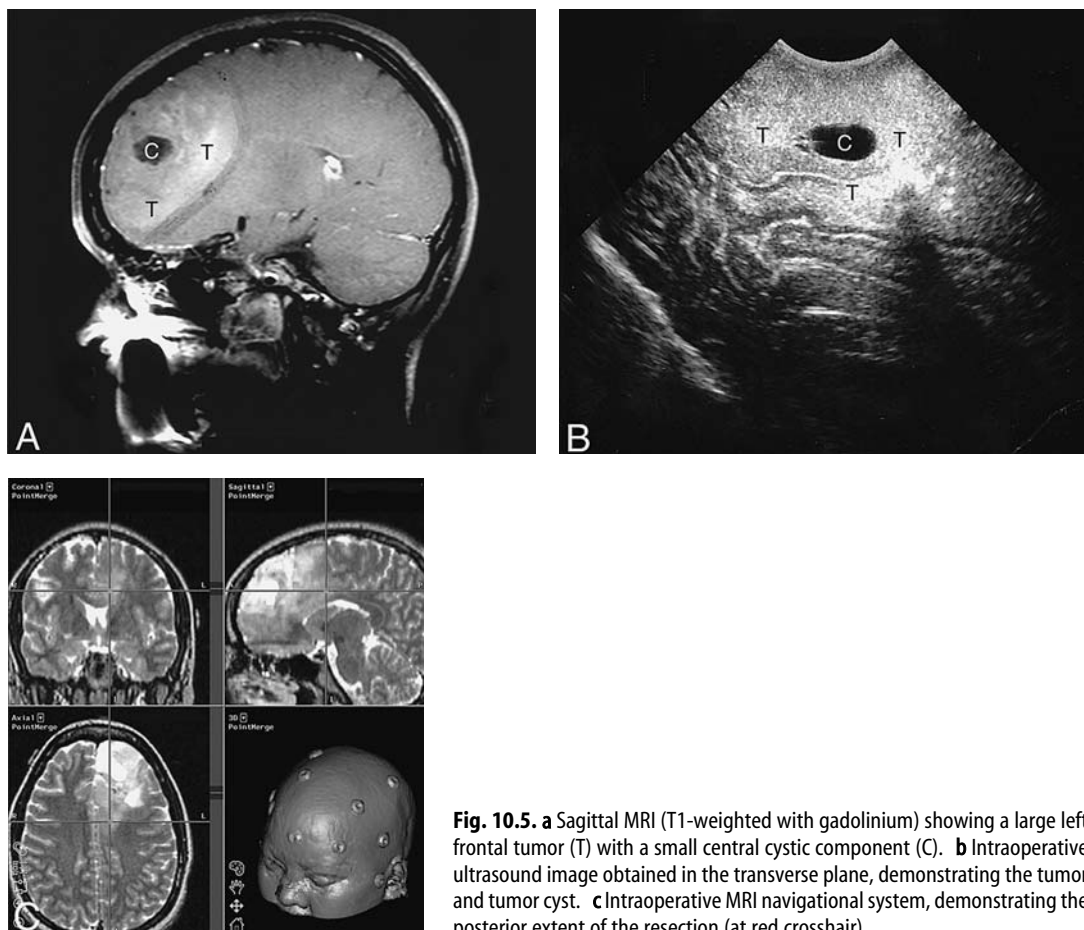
a Sagittal MRI (T1-weighted with gadolinium) showing a large left frontal tumor (T) with a small central cystic component (C). b Intraoperative ultrasound image obtained in the transverse plane, demonstrating the tumor and tumor cyst. c Intraoperative MRI navigational system, demonstrating the posterior extent of the resection (at red crosshair).
